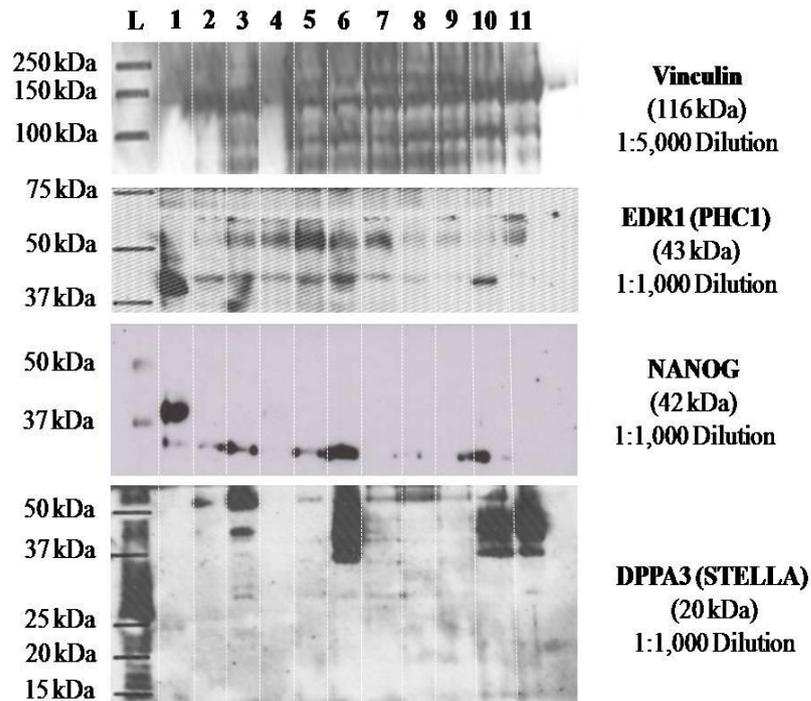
Western blotting for expression of DPPA3 (STELLA), EDR1 (PHC1), and NANOG proteins in 8 cell lines and 3 breast carcinoma tissues. Expression of DPPA3, EDR1, and NANOG proteins in one mixed germ cell tumour cell line (NCCIT), 7 breast cancer cell lines (HBL-100, MCF7, MDA-MB-231, MDA-MB-436, MDA-MB-468, T47D, and ZR-75-1) and 3 different samples of breast carcinoma tissues (DCIS, DCIS & IDC-NST, and IDC-NST) was detected by Western blotting technique. Vinculin protein was used as a loading equivalent control. NCCIT was a positive sample control for protein expression of these putative stem cell genes. Twenty-five μ g of protein sample was loaded in each lane. The protein bands were visualised after 15 minutes exposure to an X-ray film. L = Protein ladder; Lane 1 = NCCIT; Lane 2 = HBL-100; Lane 3 = MCF7; Lane 4 = MDA-MB-231; Lane 5 = MDA-MB-436; Lane 6 = MDA-MB-468; Lane 7 = T47D; Lane 8 = ZR-75-1; Lane 9 = DCIS; Lane 10 = DCIS & IDC-NST; and Lane 11 = IDC-NST
